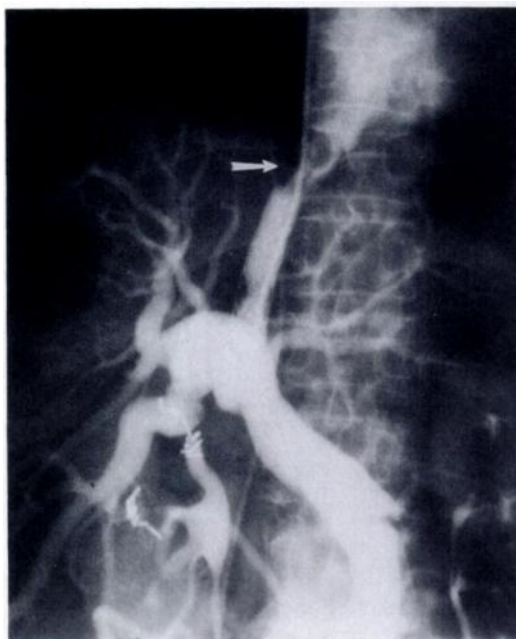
Excessively long stent. (a) Angiogram shows a Wallstent extending well into the inferior vena cava (arrow). (b) Sonogram reveals the stent projecting into the inferior vena cava (arrow).
